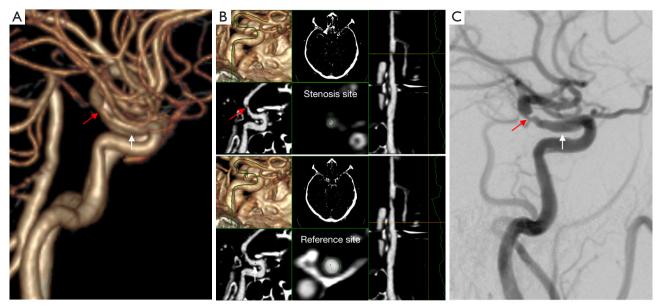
An example of measurement in ICA stenosis. An adult patient with a symptomatic ICA stenosis. The stenosis (red arrow) and reference (white arrow) sites were decided on CTA (A). The degree of stenosis was calculated as (1 – the minimal diameter at the stenosis site/the mean diameter at the reference site) × 100%, and the degree of stenosis was 71.9% on semi-automatic method (B) (red arrow indicates stenosis site; white arrow indicates reference site). The degree of stenosis was 77.0% on DSA (C) (red arrow indicates stenosis site; white arrow indicates reference site). ICA, internal carotid artery; DSA, digital subtraction angiography; CTA, computed tomography angiography.
